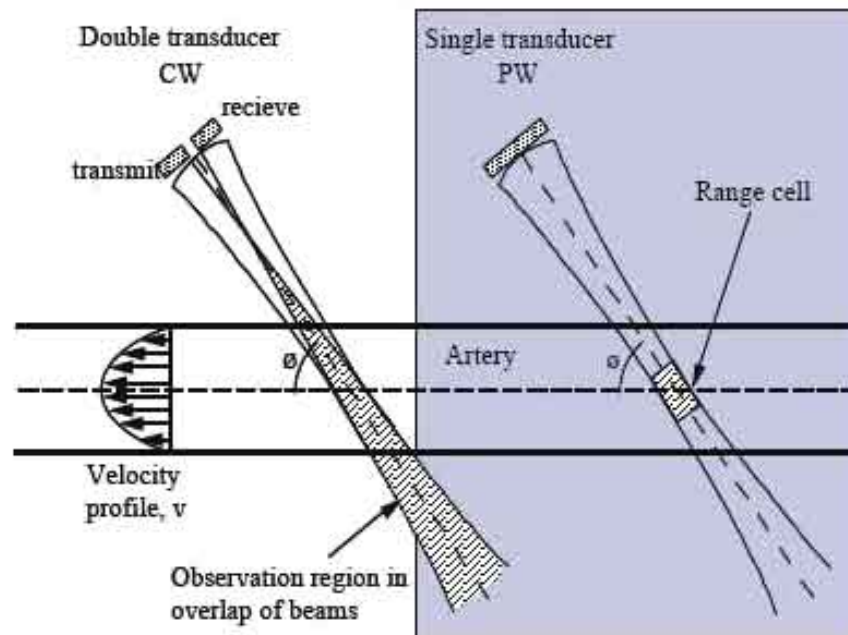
Comparison of the Continuous Wave system with the Pulsed Wave System. In the PW-implementation, only a limited sample volume is insonified, and the same transducer is used for transmitting and receiving ultrasound waves. This figure was adapted from [24].
